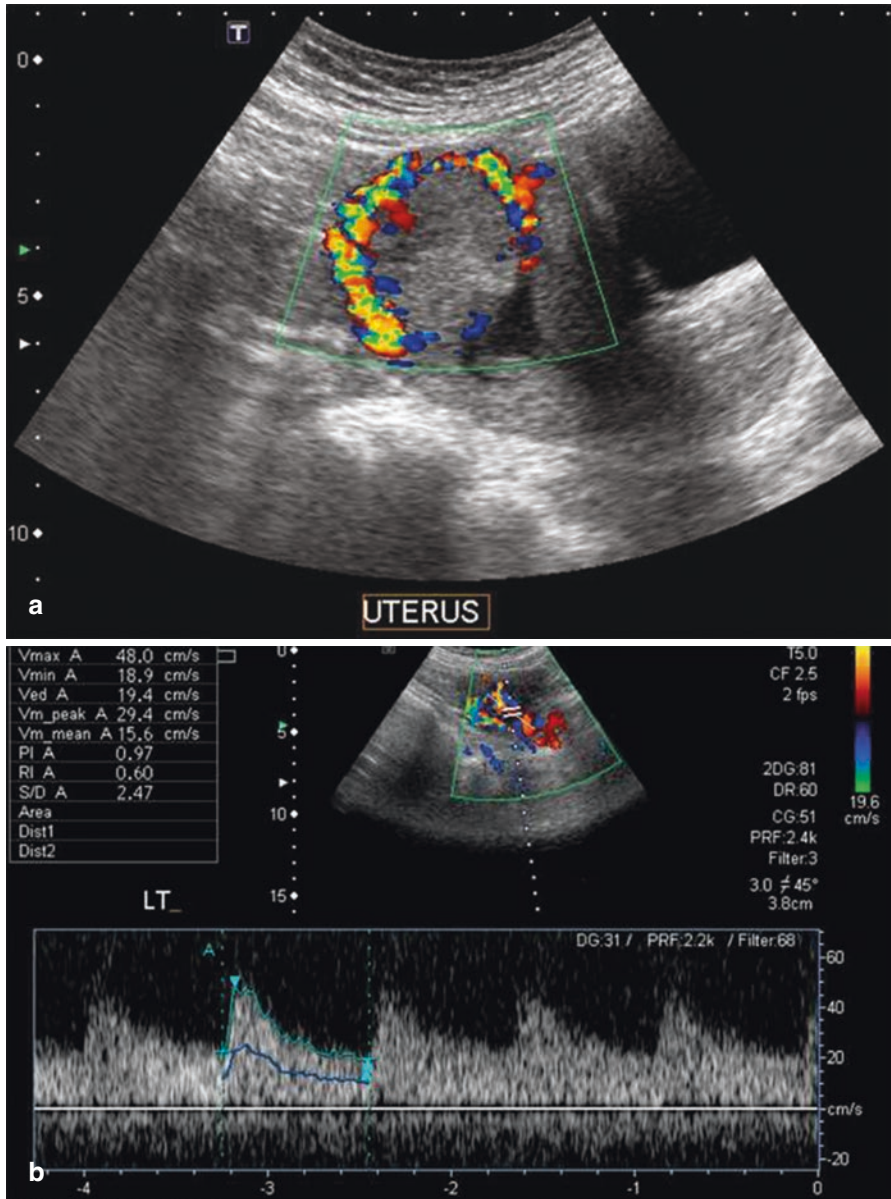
Color Doppler image (a) and Doppler flow velocimetry in choriocarcinoma in the left uterine artery (b). Notice the low pulsatility index (PI) and resistive index (RI)
